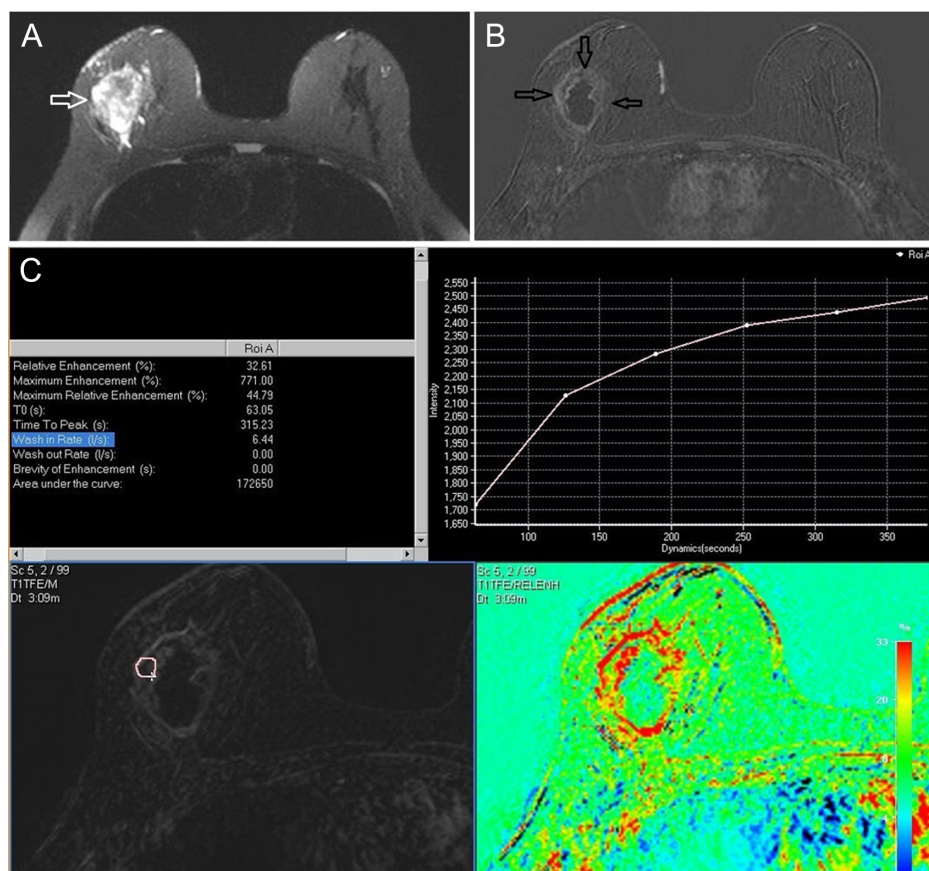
A 43-year-old woman with palpable triple-negative breast cancer of the right breast. T2-weighted with fat saturation image (A) demonstrates a 4.5-cm hyperintense mass with irregular margin and peritumoral edema in both middle and posterior segments (white arrow). Mass with irregular rim enhancement (black arrows) is seen on the postcontrast T1-weighted subtraction image (B). Measurements made from the periphery of the lesion showed a type 1 curve and areas in pink indicate a delayed persistent-type curve following slow early enhancement (C).
